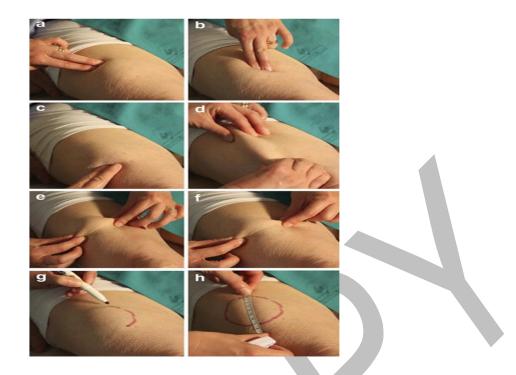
Digital palpation of injection sites. Perform repeated vertical and horizontal fingertip movements over and around the area (a–c), 'pinch' gently vertically and horizontally across the area to further facilitate identification of LH (d–f). Marking (g) and measure it if not continuing to ultrasound (h) Gentile et al. (2016).
